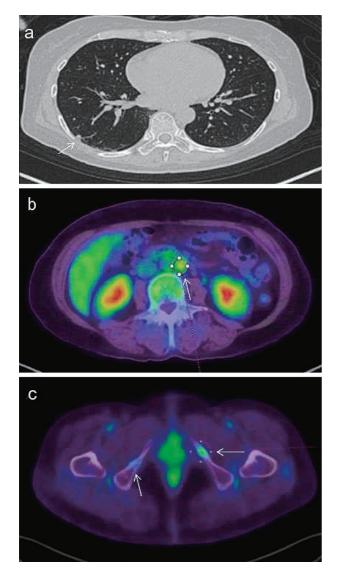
Positron emission tomography/computed tomography demonstrates multiple pulmonary metastases (a), para-aortic node metastases (b), and pelvic bone metastases (c). Arrows: each lesion.
